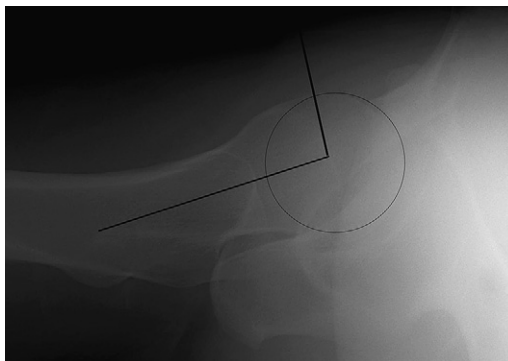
Alpha angle as measured on cross-table lateral radiograph for the diagnosis of cam impingement.
